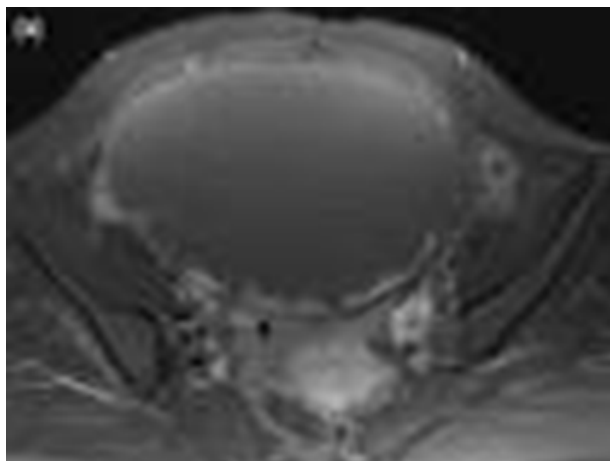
MRI of serous borderline ovarian tumor
